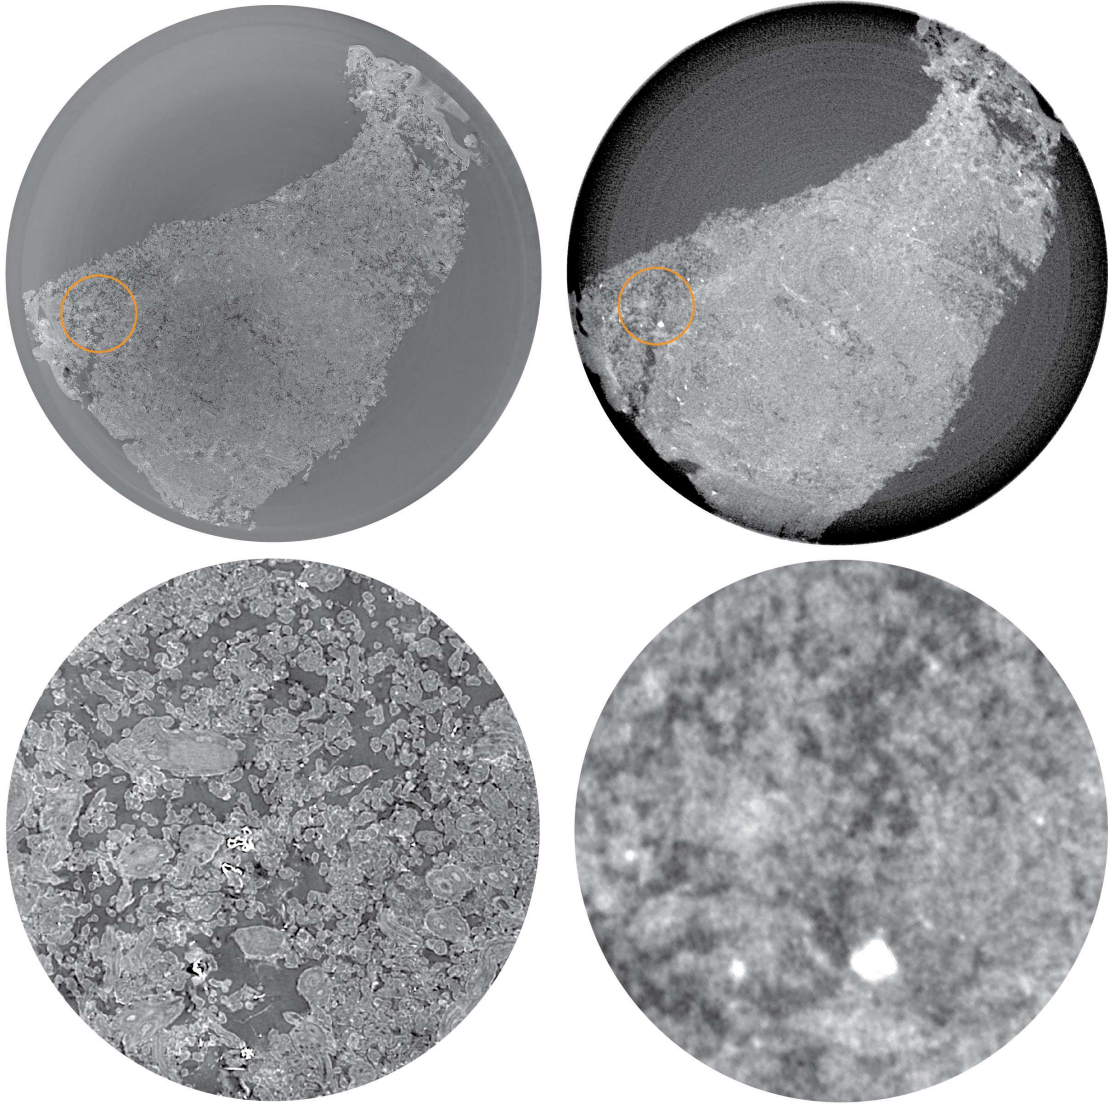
Qualitative image quality comparison between synchrotron scan (BM18-HR), left, and in-house scan right (μ CT-setup). Same sample as shown in Fig. 2 in the main manuscript.
